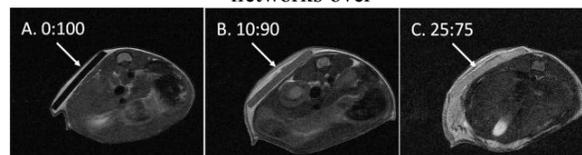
MRI images PEGDA:HDDA networks at 1 day.
